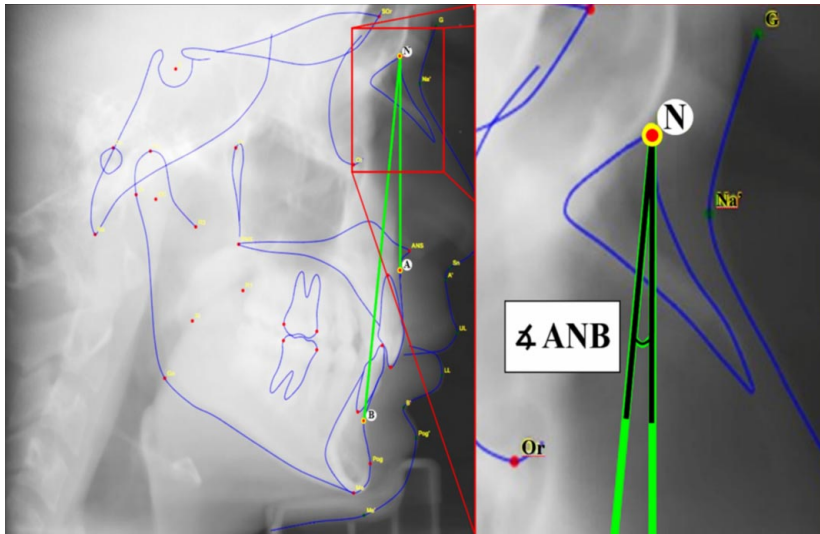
Lateral skull radiograph. Craniometric points: Craniometric points: A. Point A, B. Point B, N. Nasion point, and angle ANB.
